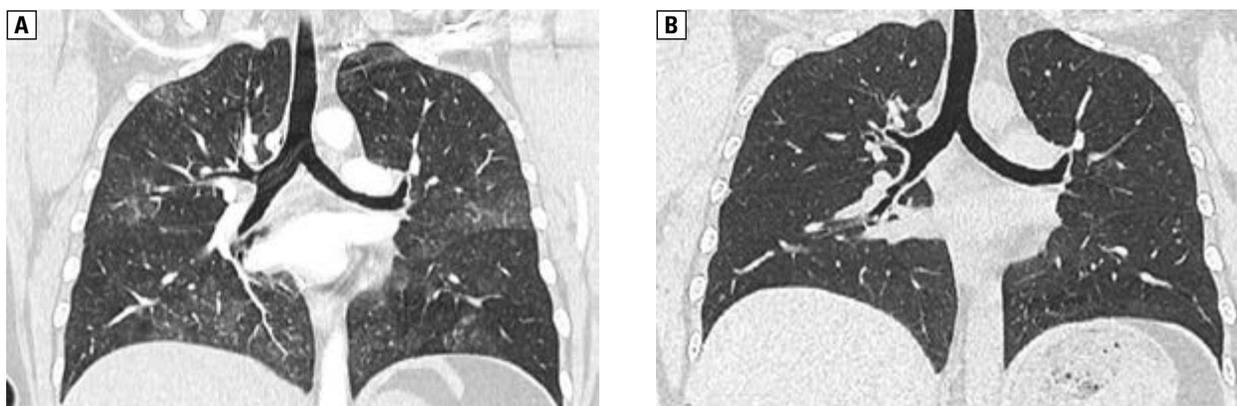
A, B. CT scans (axial reformations) show complete regression of ground-glass opacities after six months
